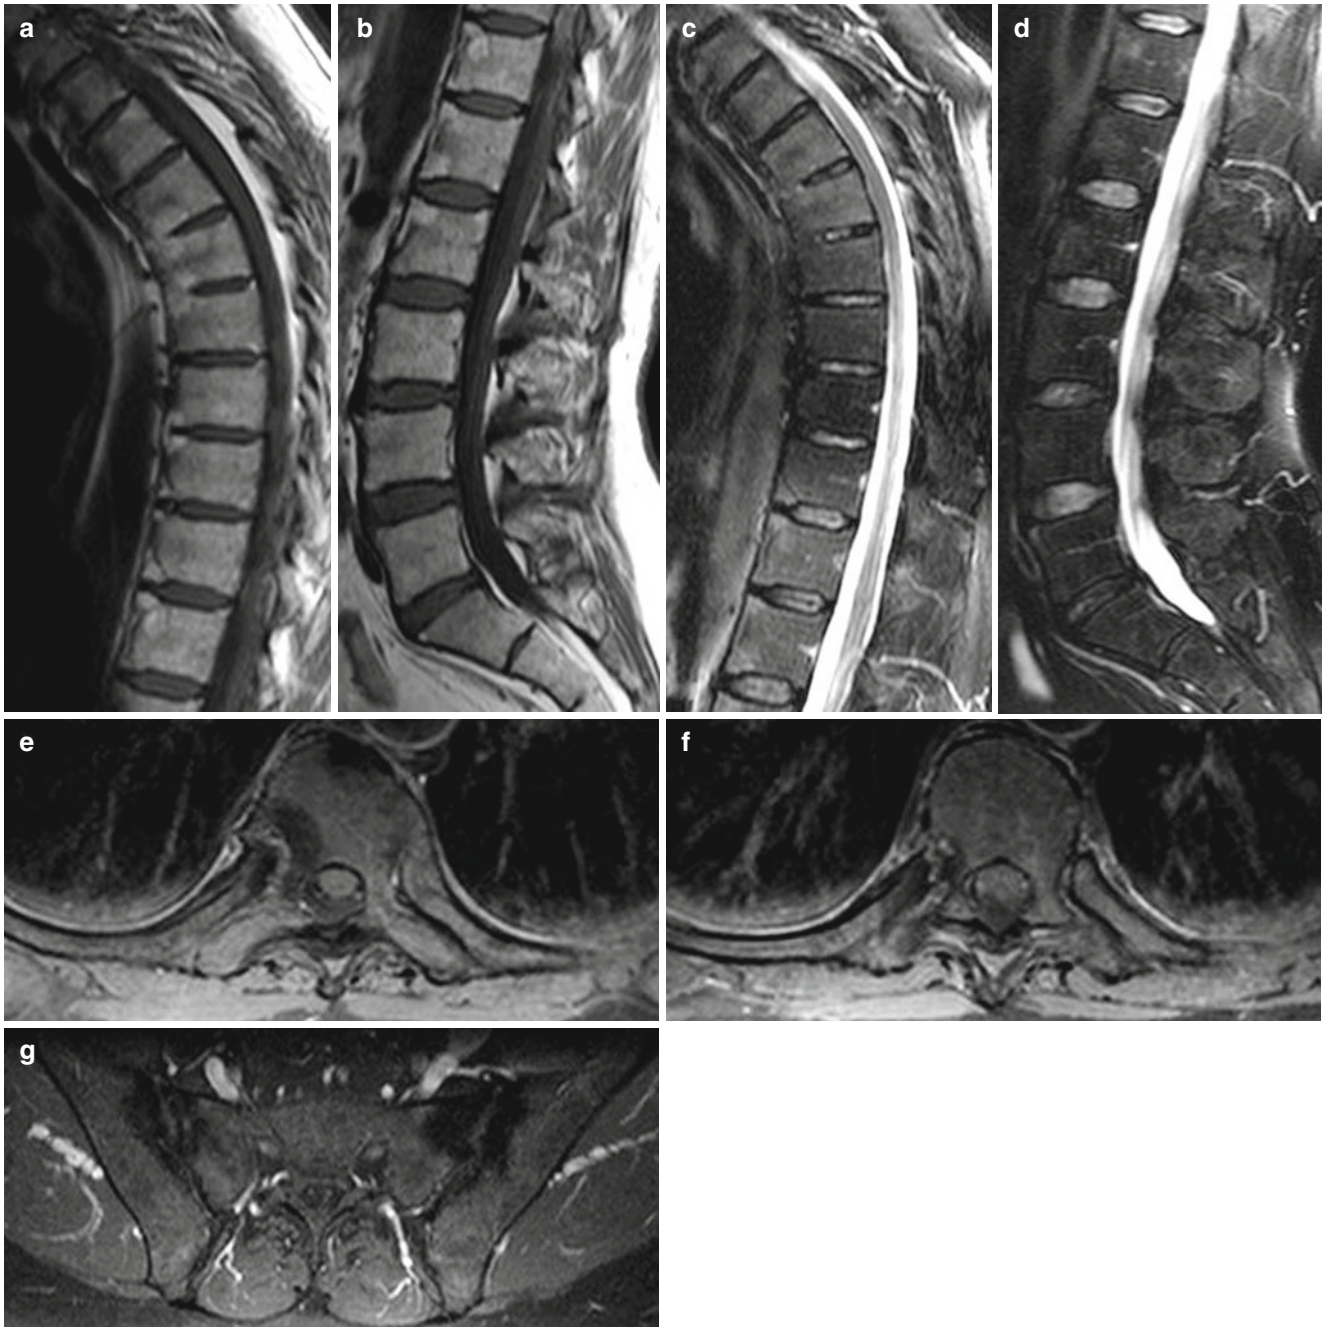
Sagittal SE T1-weighted images (a–b), sagittal TSE T2-weighted images with fat saturation (c–d), axial SE T1-weighted images with fat saturation following the administration of contrast medium (e–g). These images show ankylosis of thoracic spine (a) and fat infiltration of the corners
